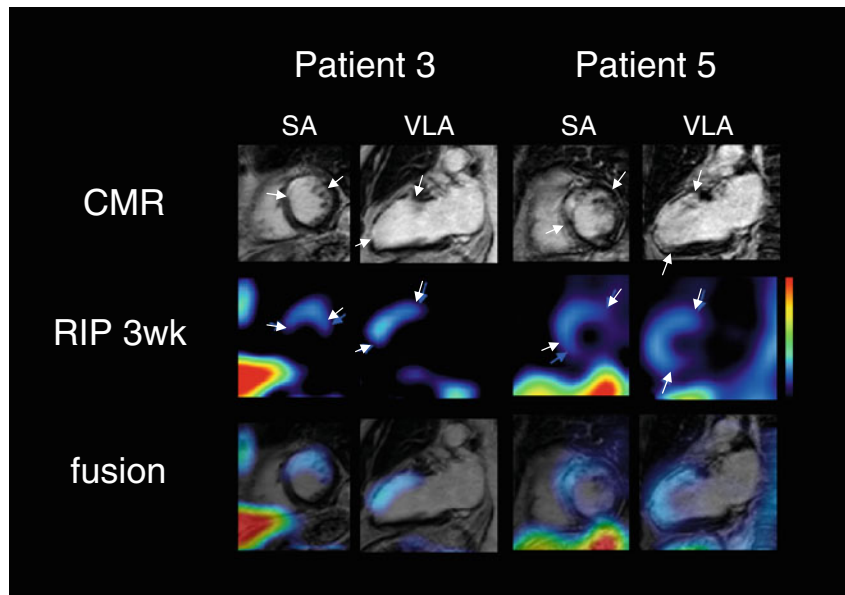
Co-localization of 3-week ^{99m}Tc -RIP uptake with CMR-verified evidence of fibrosis at 1 year. The first row demonstrates a CMR image of scar tissue in the LAD region (*white arrows*) in SA and VLA views for patients #3 and #5. The second row shows SA and VLA slices with ^{99m}Tc -RIP uptake (*blue arrows*) at 3 weeks after MI, corresponding to scar formation as determined by CMR after 1 year (*blue vs white arrows*). The last row shows SPECT/MR fusion images.
